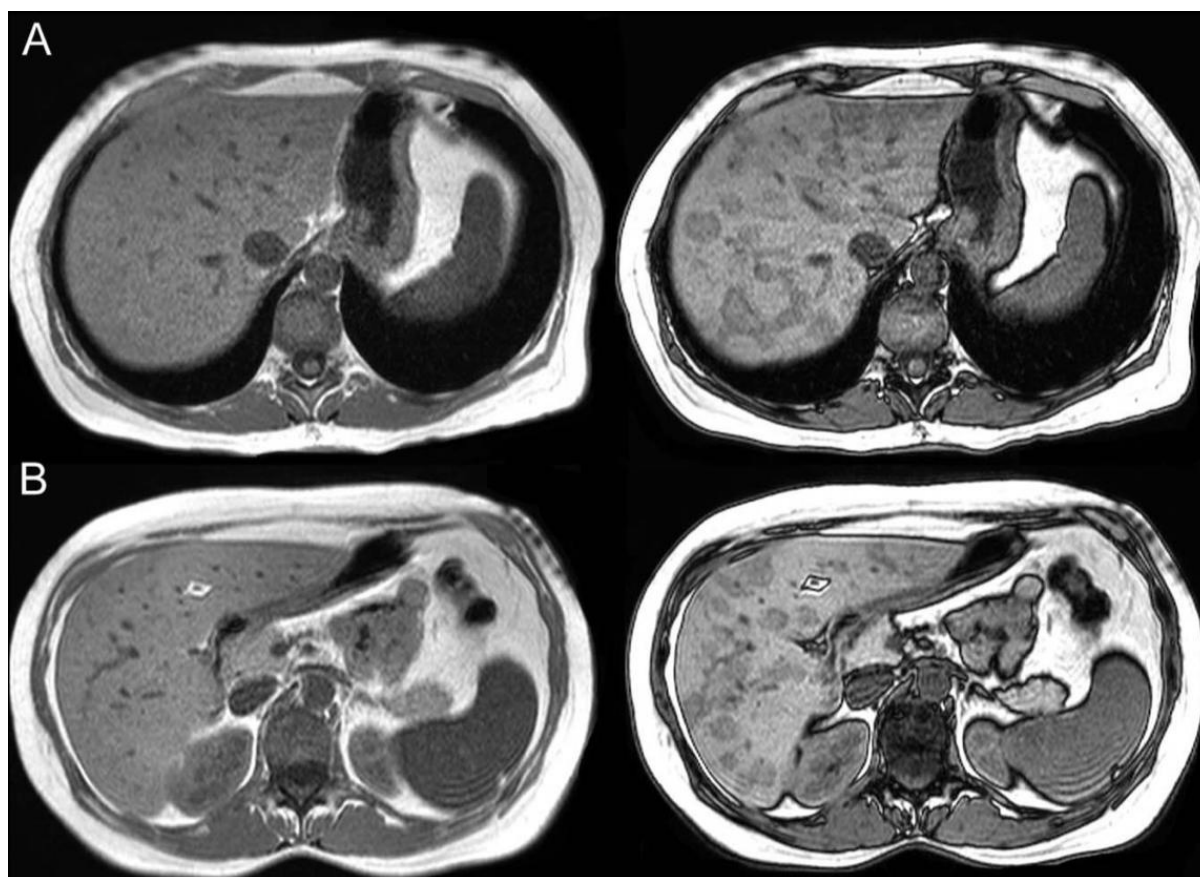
(A and B) Liver magnetic resonance imaging out-phase (left) and in-phase (right) image showing signal drop on the latter, indicating intracellular lipid content into hepatic lesions.
